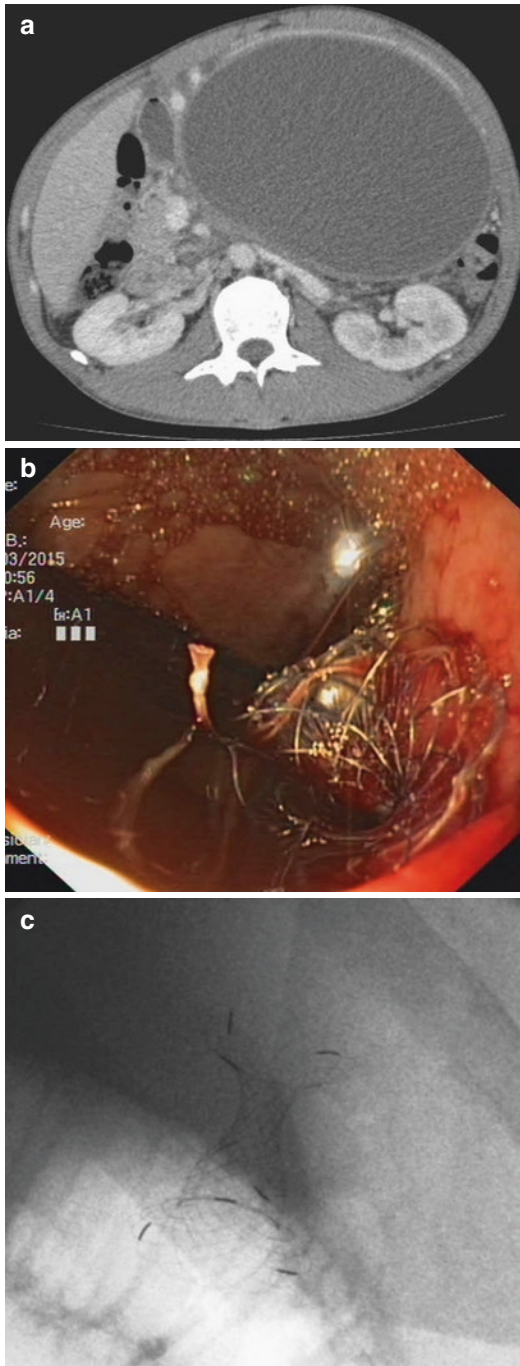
(a) Computed Tomography of a patient with a large pancreatic pseudocyst. (b) Endoscopic view of pseudocyst drainage using a lumen-apposing SEMS. (c) X-ray view of the SEMS
